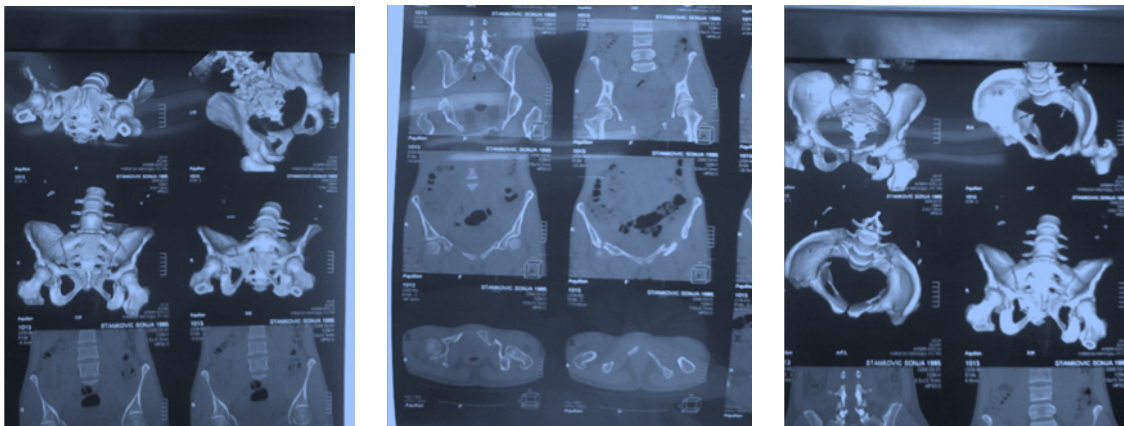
CT scan of a patient with IAIT injury and fractures of the acetabulum caused by lateral effect of high energy force
